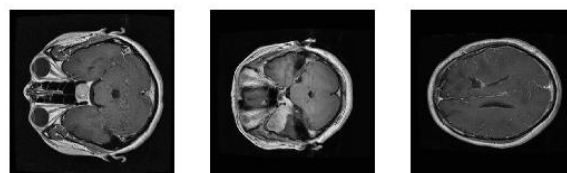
MRI images of the Figshare dataset utilized for brain tumor classification
